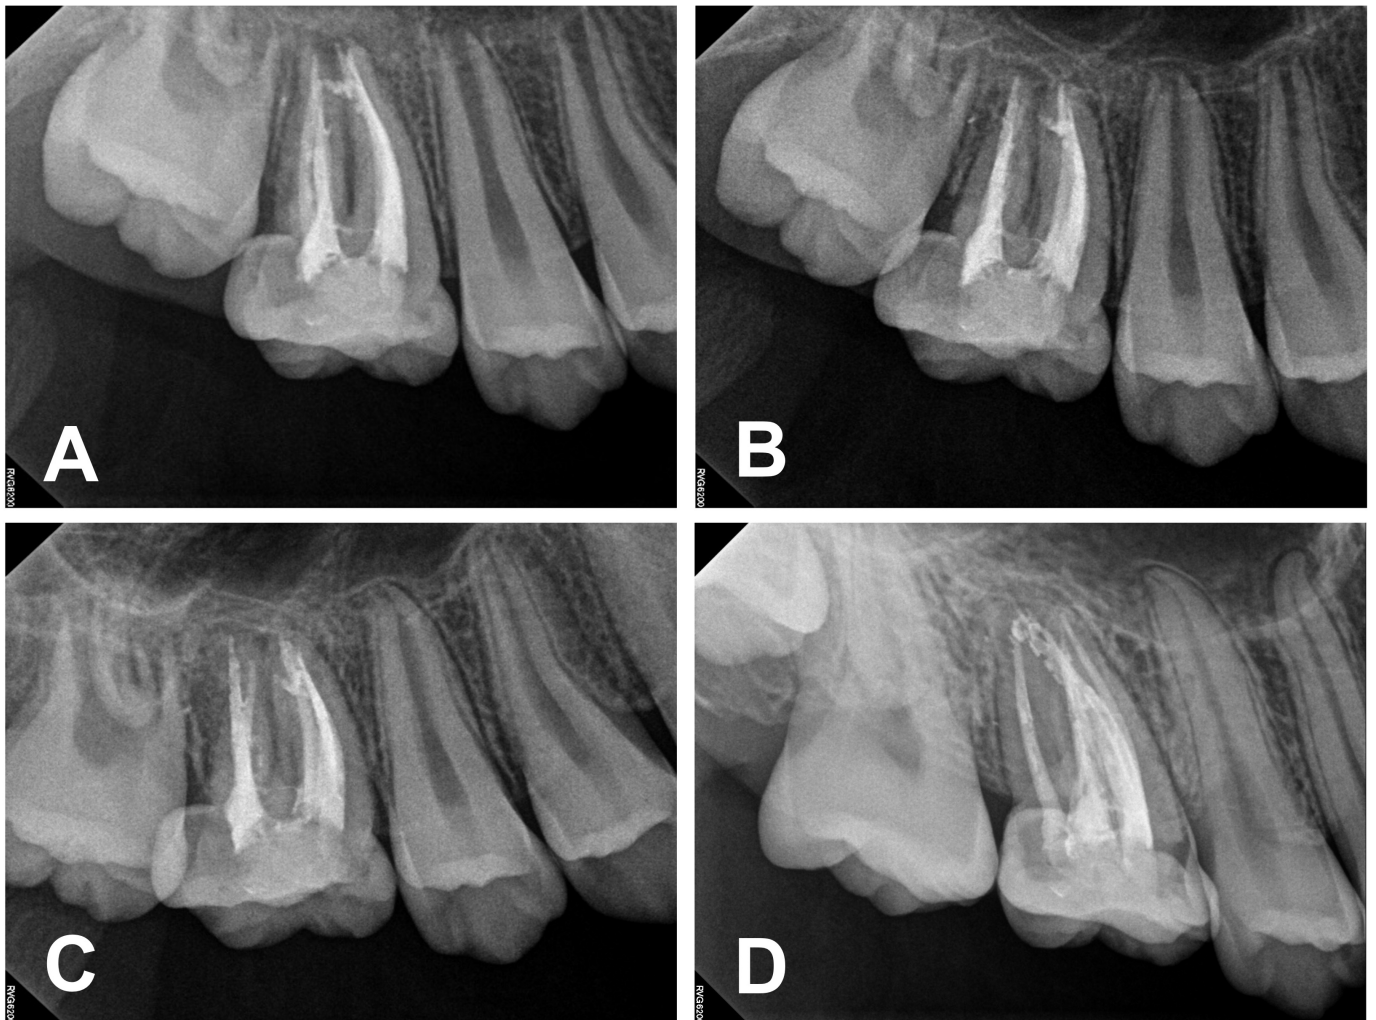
Periapical radiographs at follow-up recalls: (A) 1 month, (B) 6 months, (C) 1 year, and (D) 6 years. All radiographs demonstrate normal, healed periapical tissue.
